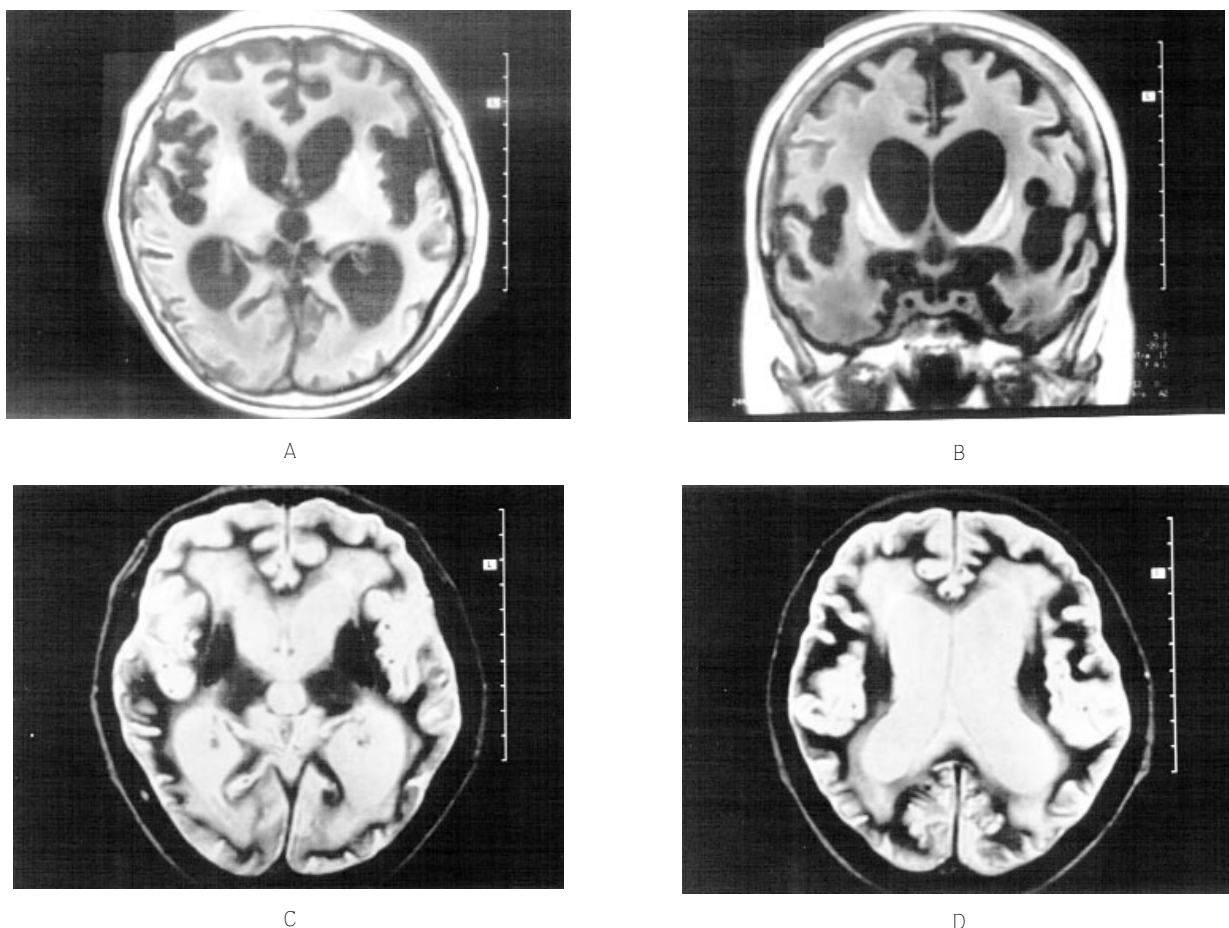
(A) Axial, (B) coronal, T1W (15/600 ms), and (C-D) axial T2W (80/2000 ms) SE sequences show bihemispherical cerebral and cerebellar atrophy and ventricular dilatation; hyperintensity in periventricular white matter on T2W SE sequences probably due to myelin loss; glial proliferation; microinfarcts; and extracellular edema. There were signal void regions on T2W and hyperintense regions on T1W SE sequences probably due to pigment deposition in necrotic ground especially in the putamen, head of the caudate nucleus and periventricular area. The correlated well with CT appearance (Fig. 4B).
